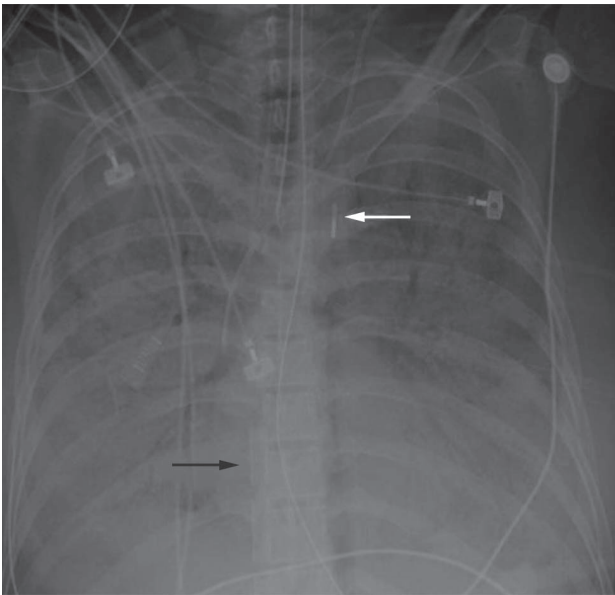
Chest radiograph showing diffuse opacities. The tip of the intra-aortic balloon pump is seen above the left main bronchus (white arrow). The ECMO venous cannula terminates at the right atrium (black arrow).
